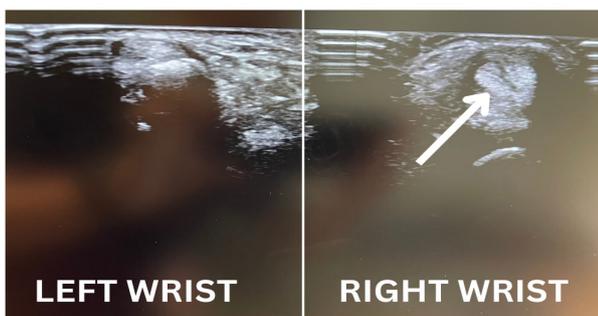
Ultrasound comparison of extensor carpi ulnaris (ECU) tendon below the ulnar styloid during first visit to sports medicine clinic. Noted the right ECU is swollen with surrounding fluids suggestive of tenosynovitis and presence of split tear. The synovial sheath also appears thickened. Noted that small fluids surrounding left ECU is normal.
